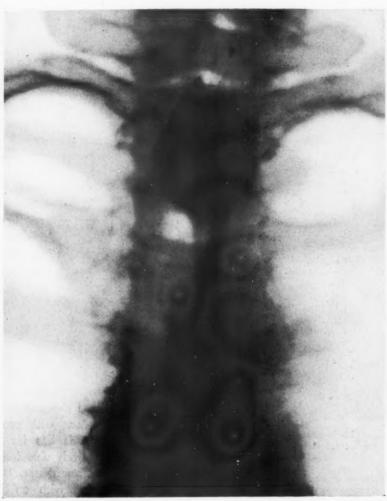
Based upon this roentgenogram, without a lateral view, this patient was operated upon for an esophageal diverticulum which proved to be only a dilatation. Had a lateral view been taken, it would have been demonstrated that there was no spill-over, as shown in Figure 9, which is a true esophageal diverticulum.
